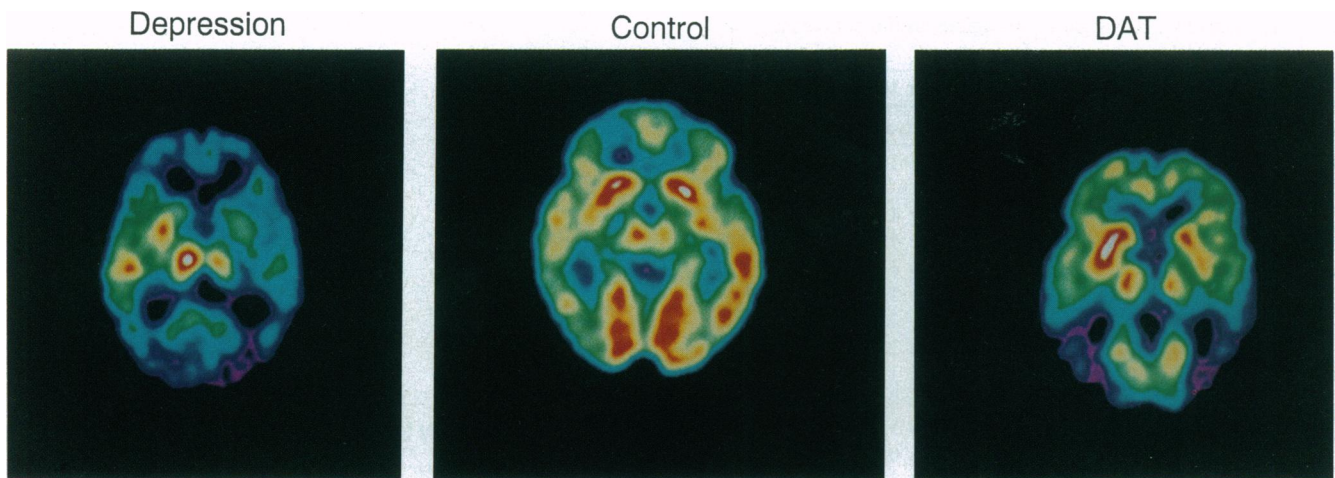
^{18}F FDG uptake in the cortical and subcortical regions at the level of the basal ganglia in late-life depression, DAT, and an age-matched control. Orange and red show areas of high FDG uptake; green and blue represent regions with low FDG uptake. The right side of the image represents the left side of the brain and vice versa. Note the widespread decline in FDG uptake that occurs in late-life depression and DAT relative to the control.
